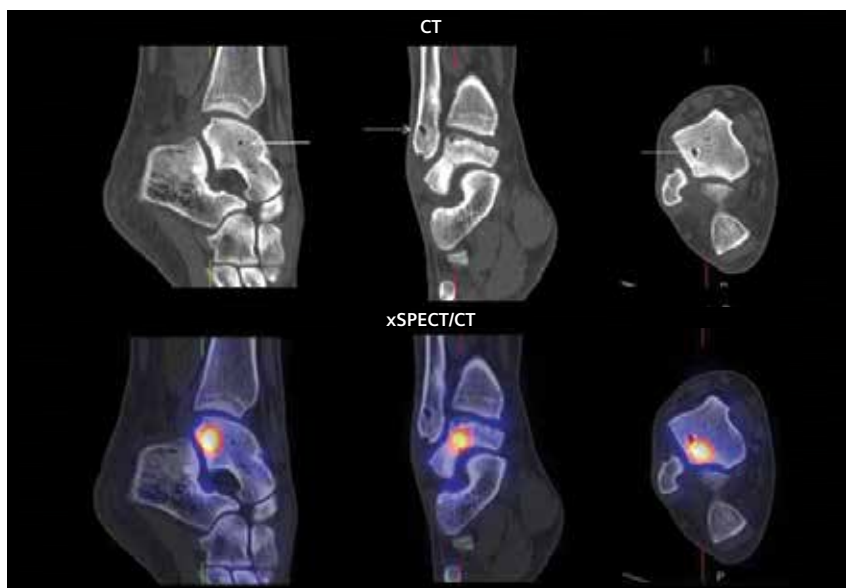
CT and fusion of CT and xSPECT Bone images at slightly different slice and orientation levels show talar tunnel separate from the talar cyst as well as the fibular tunnel drilled as part of the fixation procedure. The focal hypermetabolism can be well localized to a part of the talus posterior to the cyst and adjacent to part of the talo-calcaneal joint.
